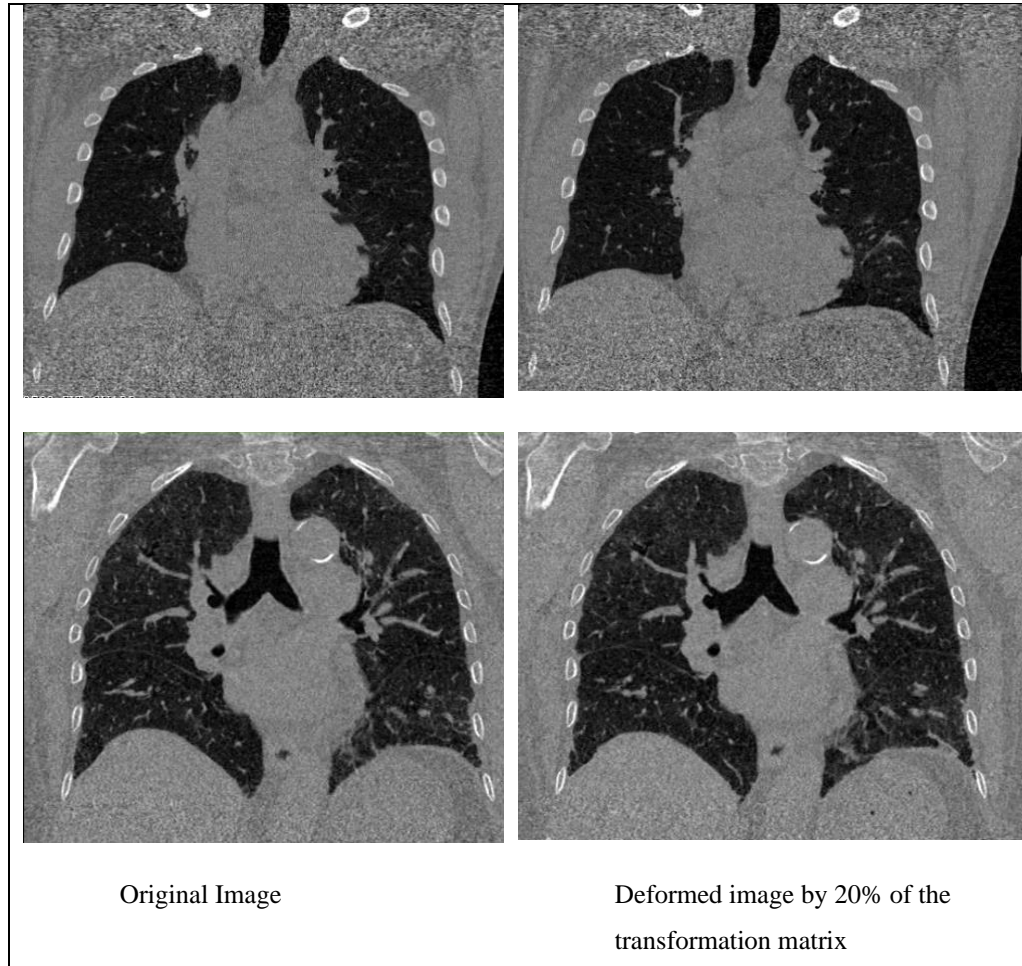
Examples of coronal views of original and corresponding lung CT scans.
